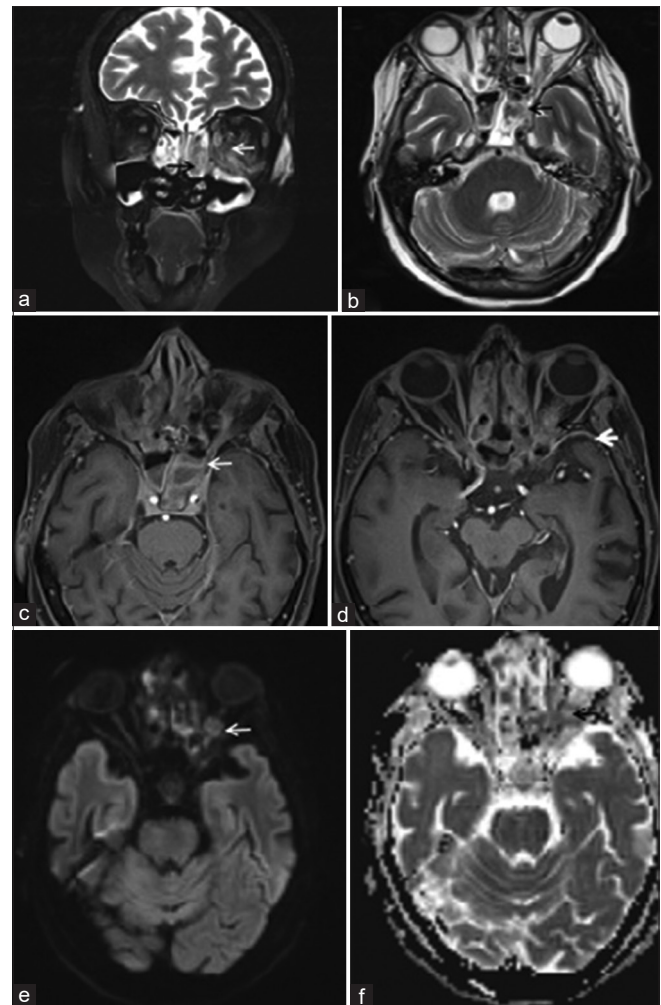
Mucormycosis with orbital involvement (optic neuritis with abscess). (a) Coronal fat suppressed T2 weighted image showing T2 hypointense (necrotic) contents in ethmoid air cells (black arrow) and hyperintense bulky extraocular muscles (white arrow) with intraconal and extraconal fat stranding, (b) Axial T2 weighted image demonstrates hypointense contents in sphenoid sinus with optic canal involvement (black arrow), (c and d) Axial postcontrast fat suppressed T1 weighted images showing peripheral enhancement along optic nerve at optic canal (white arrow) with ill-defined enhancing lesion in optic nerve (black arrow). There is adjacent dural enhancement along temporal convexity (thick white arrow), (e and f) Axial DWI and ADC images show peripheral restricted diffusion (white arrow) and corresponding ADC drop (black arrow) within lesion in optic nerve. DWI: Diffusion weighted imaging, ADC: Apparent diffusion coefficient
